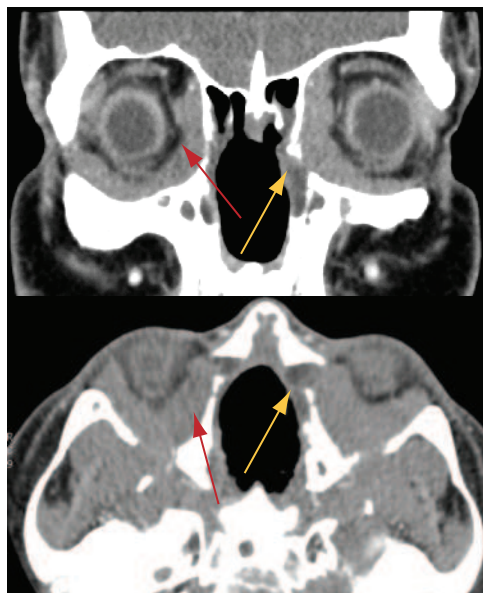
CT scans of a patient demonstrating bilateral orbital granulomatosis with polyangiitis (*red arrows*) and secondary nasolacrimal duct obstruction (*yellow arrows*). (Courtesy of Bobby S. Korn, MD, PhD.)
